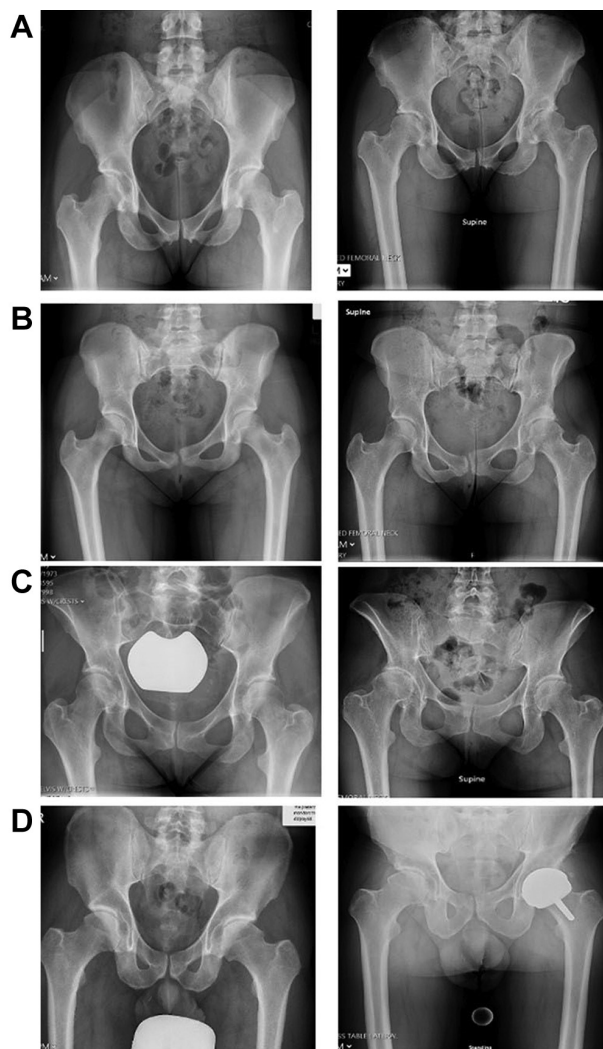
Example anteroposterior radiographs obtained in patients with FAIS both (left) preoperatively and (right) >10 years postoperatively. (A) Radiograph obtained in a 29-year-old woman who underwent right hip arthroscopy and developed comparatively worse progressive osteoarthritis in the nonoperative left hip at age 41 years. (B) Radiograph obtained in a 19-year-old woman who underwent right hip arthroscopy and developed comparatively worse progressive osteoarthritis in the nonoperative left hip at age 31 years. (C) Radiograph obtained in a 38-year-old woman who underwent left hip arthroscopy and developed comparatively worse progressive osteoarthritis in the nonoperative right hip at age 49 years. (D) Radiograph obtained in a 45-year-old man who underwent right hip arthroscopy and maintained arthroplasty-free survivorship compared with the left hip that underwent hip resurfacing arthroplasty when the patient was 57 years of age.
